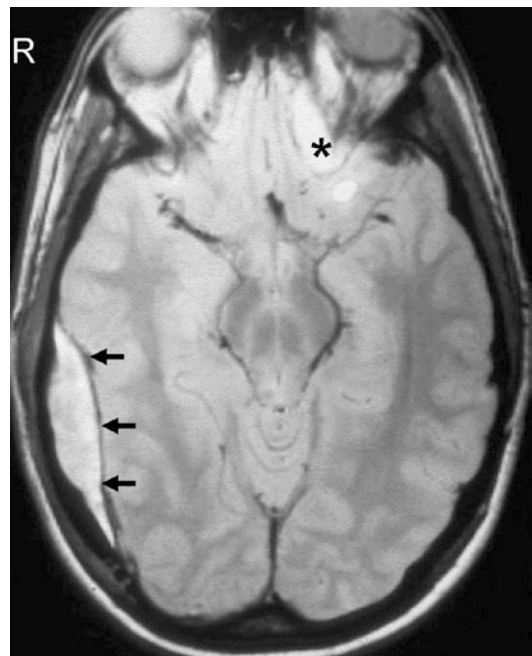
Subacute EDH on MRI. Proton density-weighted axial MR image shows a thin dark line (*horizontal arrows*) displaced by the extra-axial collection, indicating the epidural location of the hematoma. A contrecoup left orbitofrontal contusion is also evident (*asterisk*). (Reprinted with permission of Wolters Kluwer from Gean [148])
